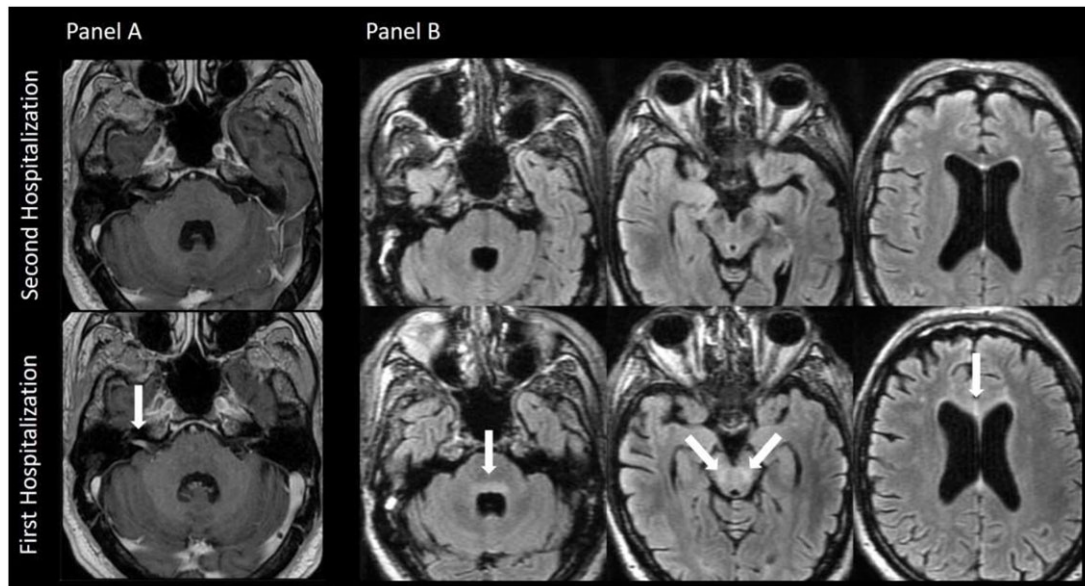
MRI brain with gadolinium during the first and second hospitalizations (four months apart). Panel a) Axial 3D T1-weighted post-gadolinium images of the brain from the first and second hospitalizations demonstrate interval enlargement of abnormal enhancement in the right internal auditory canal. Panel b) Axial 3D T2-weighted FLAIR images of the brain from the first and second hospitalizations demonstrate several new areas of relatively symmetric abnormal signal hyperintensity involving the periventricular dorsal pons, the cerebral peduncles bilaterally, and the corpus callosum.
